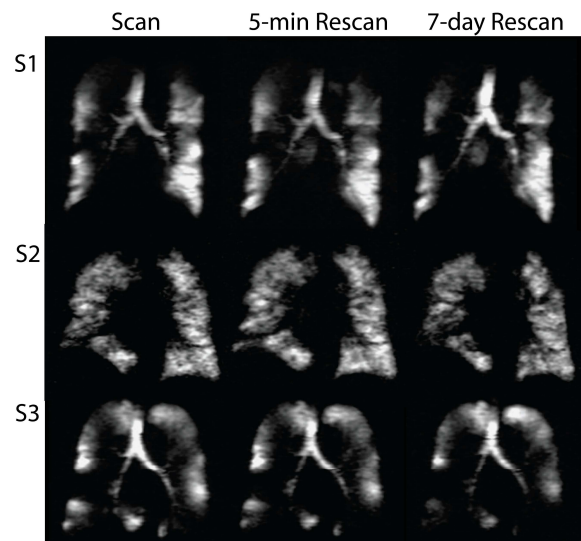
¹²⁹Xe MRI at scan, 5-min rescan and 7-day rescan for all three COPD subjects.
